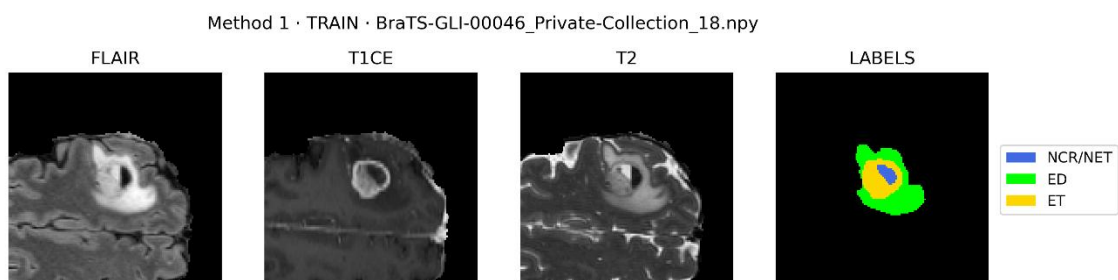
Example of FLAIR, T1GD, and T2 slices from the train set, with the corresponding segmentation labels showing necrotic core, ED, and enhancing tumor.
